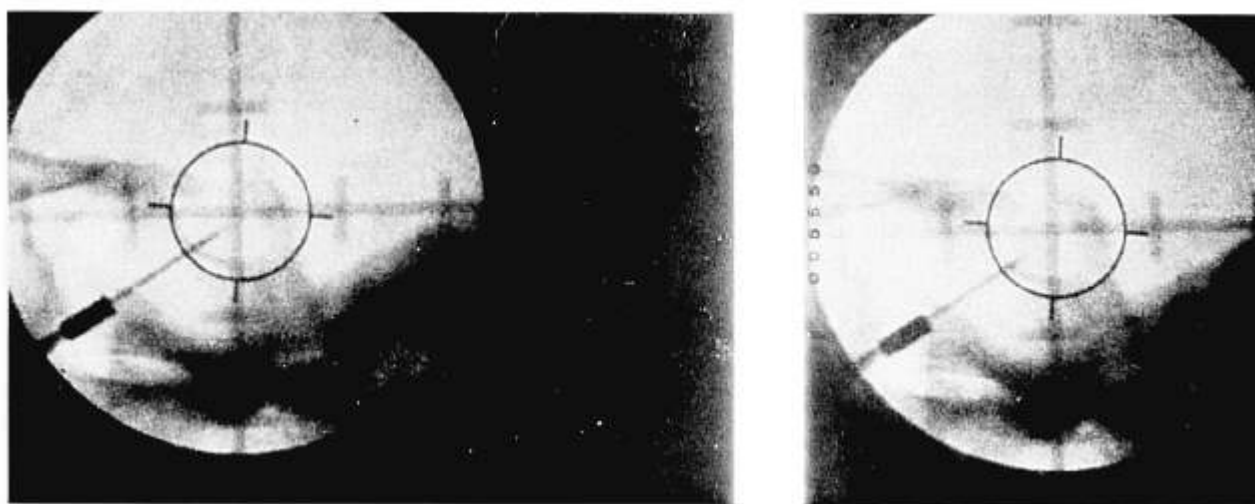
Radiograph showing two positions of spinal needle during alcohol injection.
